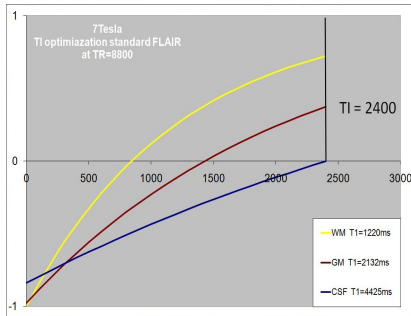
TI optimization standard FLAIR
